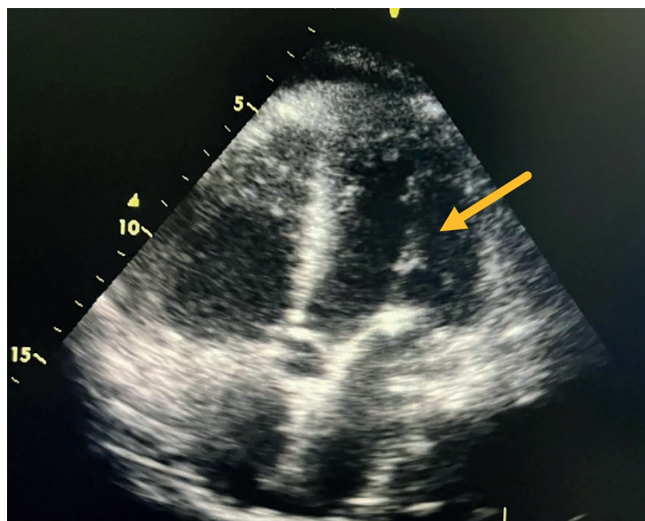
Echocardiogram with evidence of mitral valve lesion and pericardial effusion.
